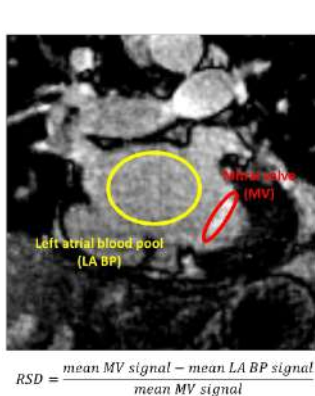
Computing relative signal difference (RSD). Example LGE MRI with ROI drawn around the enhanced mitral valve (MV) and the left atrial blood pool (LA BP) and equation for computing RSD.
